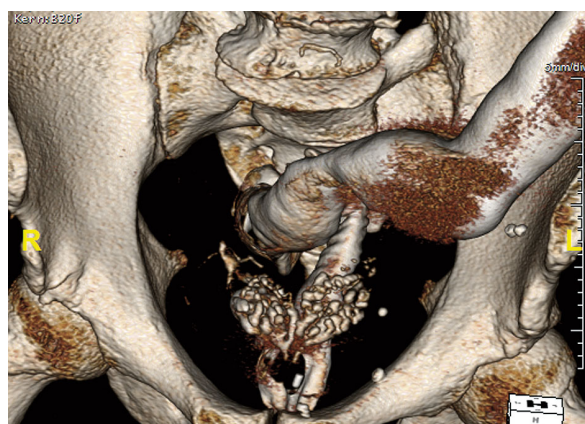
3D reconstruction of the computed tomography irrigoscopy
